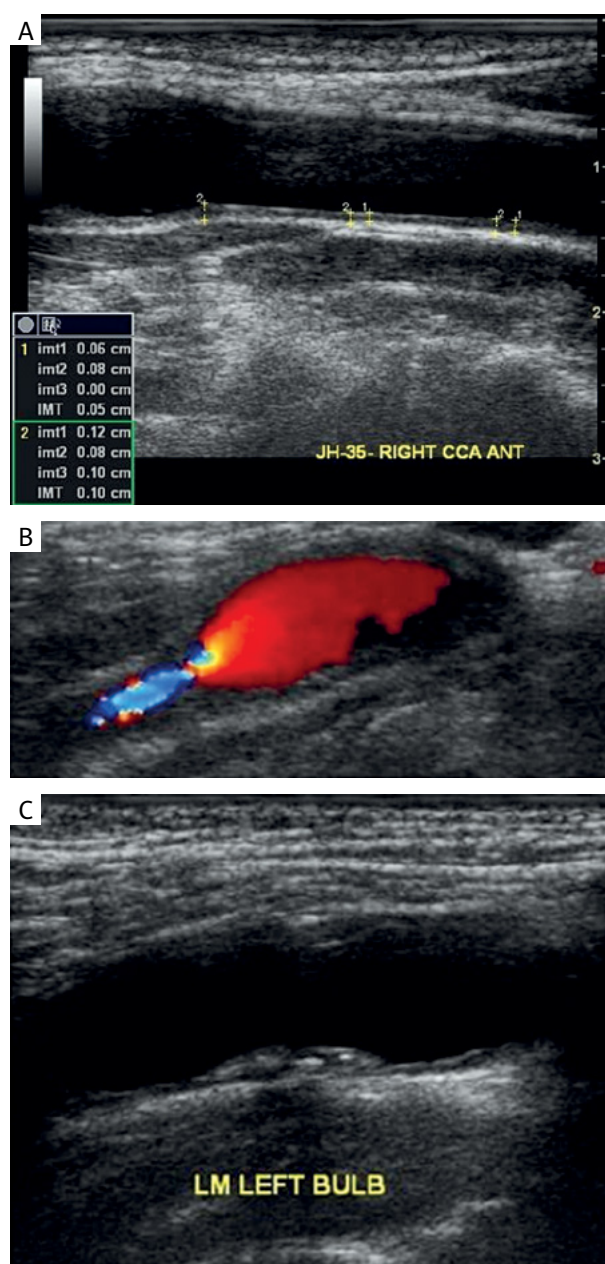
Carotid arteries ultrasound (2008)
